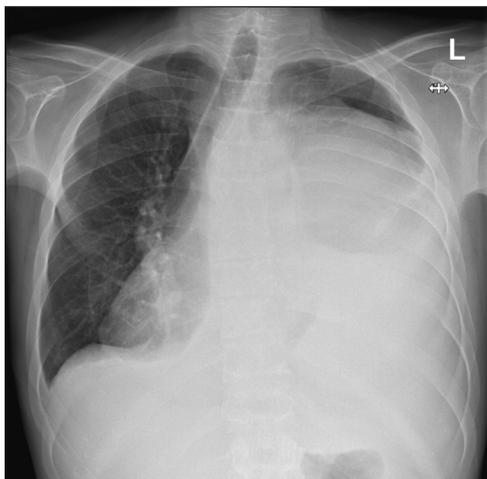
X-ray chest reveals near complete opacification of left lung field with cardio-mediastinal shift to the right
